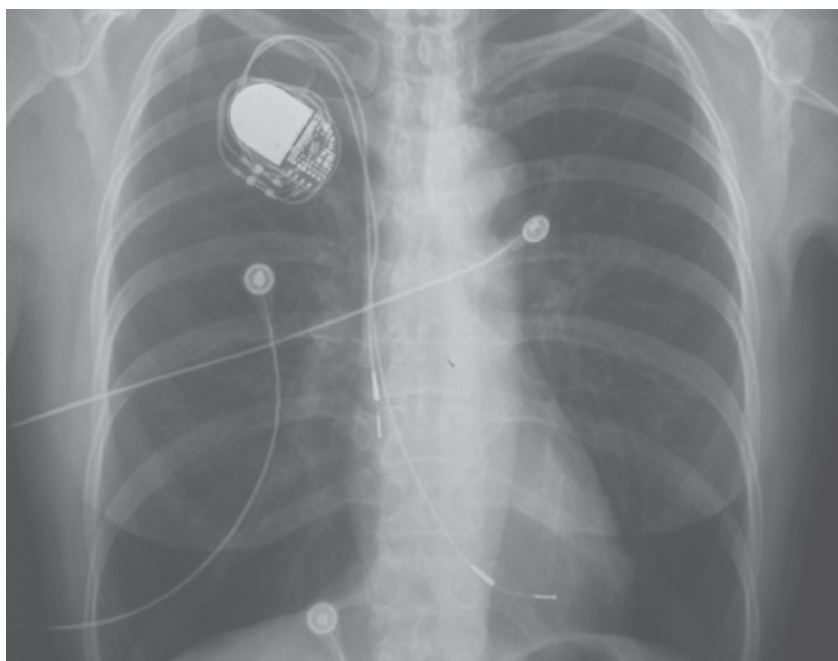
Chest X-ray showing migration of both atrial and ventricular leads.
